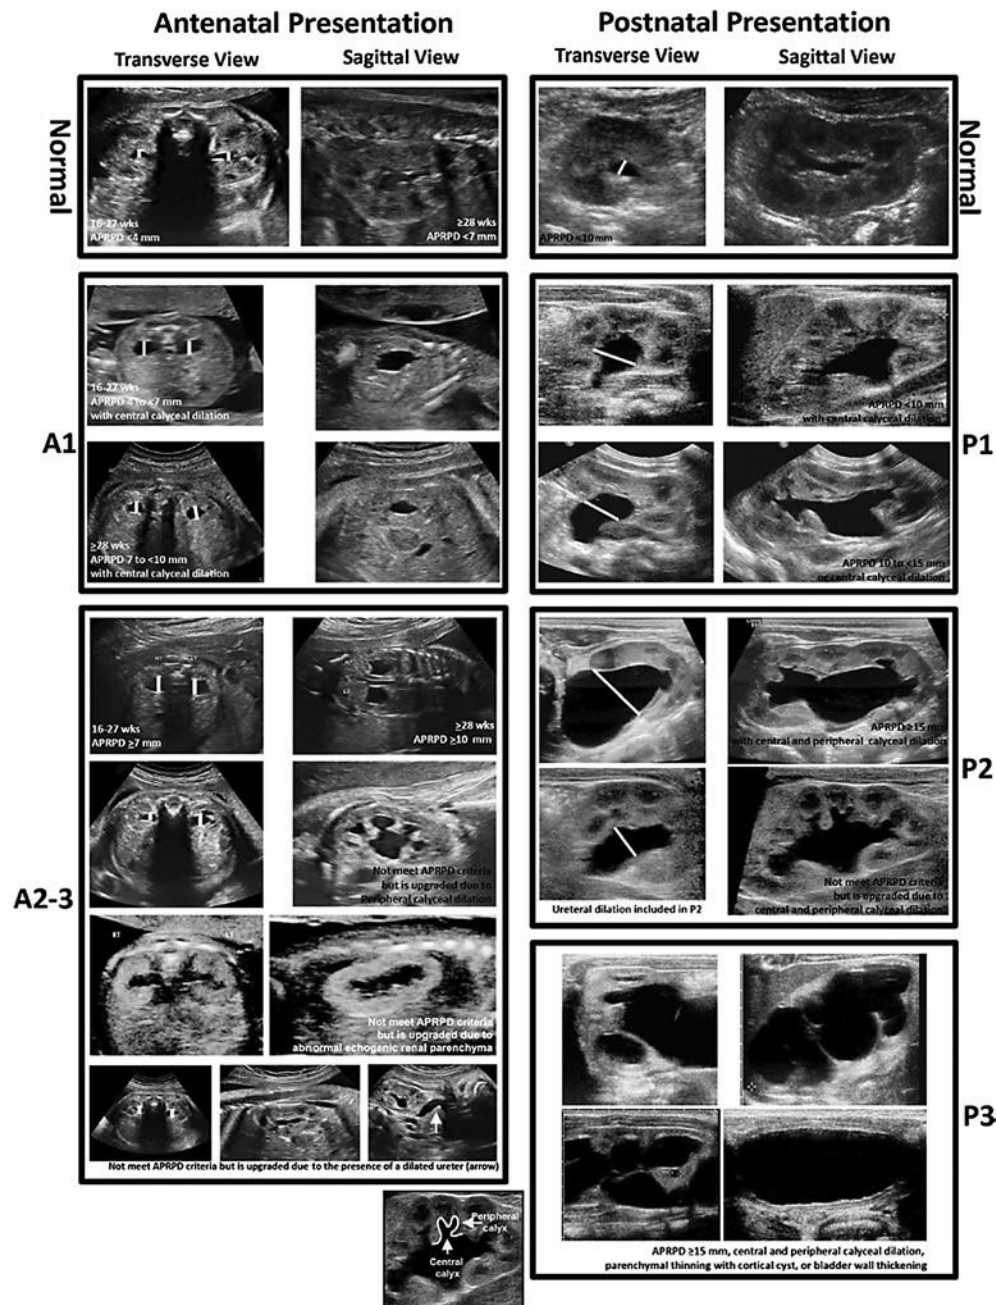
The urinary tract dilation (UTD) classification system, which describes the appearance of the urinary tract based on antenatal and postnatal presentation. Antenatal presentation (*left column*) is divided into normal, A1, and A2-3, and measurements between 16 and 27 weeks and 28 or more weeks of gestation. A normal urinary tract is one with no urinary tract abnormalities and anteroposterior renal pelvic diameter (APRPD) measuring less than 4 mm between 16 and 27 weeks' gestation and less than 7 mm at 28 or more weeks of gestation. A1 describes a normal urinary tract with 4 to less than 7 mm pelvic dilation at 16 to 27 weeks' gestation or 7 to less than 10 mm at 28 or more weeks of gestation with or without central calyceal dilation. UTD A2-3 is for fetuses with APRPD of 7 mm or more between 16 and 27 weeks' gestation or 10 mm or greater at 28 or more weeks of gestation, peripheral calyceal dilation, ureteral dilation, renal parenchymal, or bladder abnormalities. The postnatal presentation (*right column*) is divided into normal, P1, P2, and P3. Measurements are more reliable if taken 48 hours after birth or later. A normal urinary tract is one with no urinary tract abnormalities and APRPD less than 10 mm. P1 describes a normal urinary tract with APRPD 10 to less than 15 mm or central calyceal dilation. P2 describes APRPD 15 mm or more or peripheral calyceal dilation. P3 describes additional ureteral dilation, abnormal renal echogenicity, or cysts or bladder abnormalities regardless of APRPD measurement. (From Chow JS, Benson CB, Lebowitz RL: The clinical significance of an empty renal fossa on prenatal sonography. *J Ultrasound Med* 24(8):1049-1054, 2005.)
